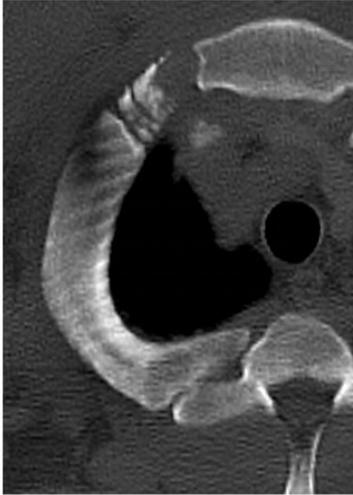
The CT image of the fourth cartilage stage.
